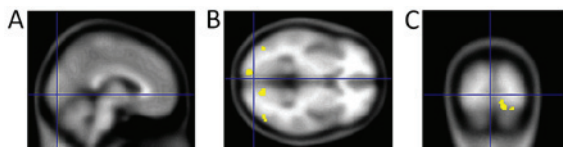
Functional magnetic resonance imaging following visual paradigm, using black and white chessboard in the same patient as in Fig. 3. The examination was performed in 2010. Yellow areas indicate increased activity. (A) Sagittal section, (B) transverse section and (C) coronal section based on Lestak *et al* (25).
